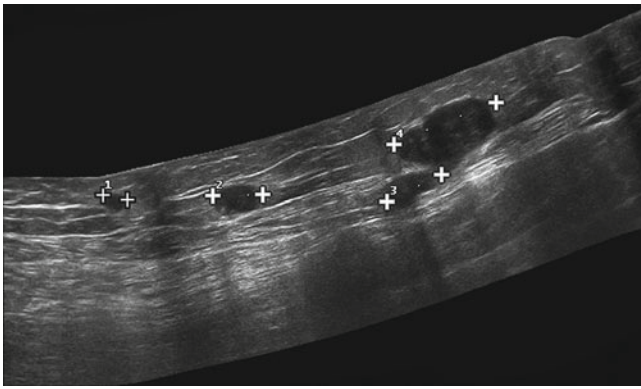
Extended field of view (ultrasound allowing depiction and measurement of multiple melanoma metastases of the thigh
